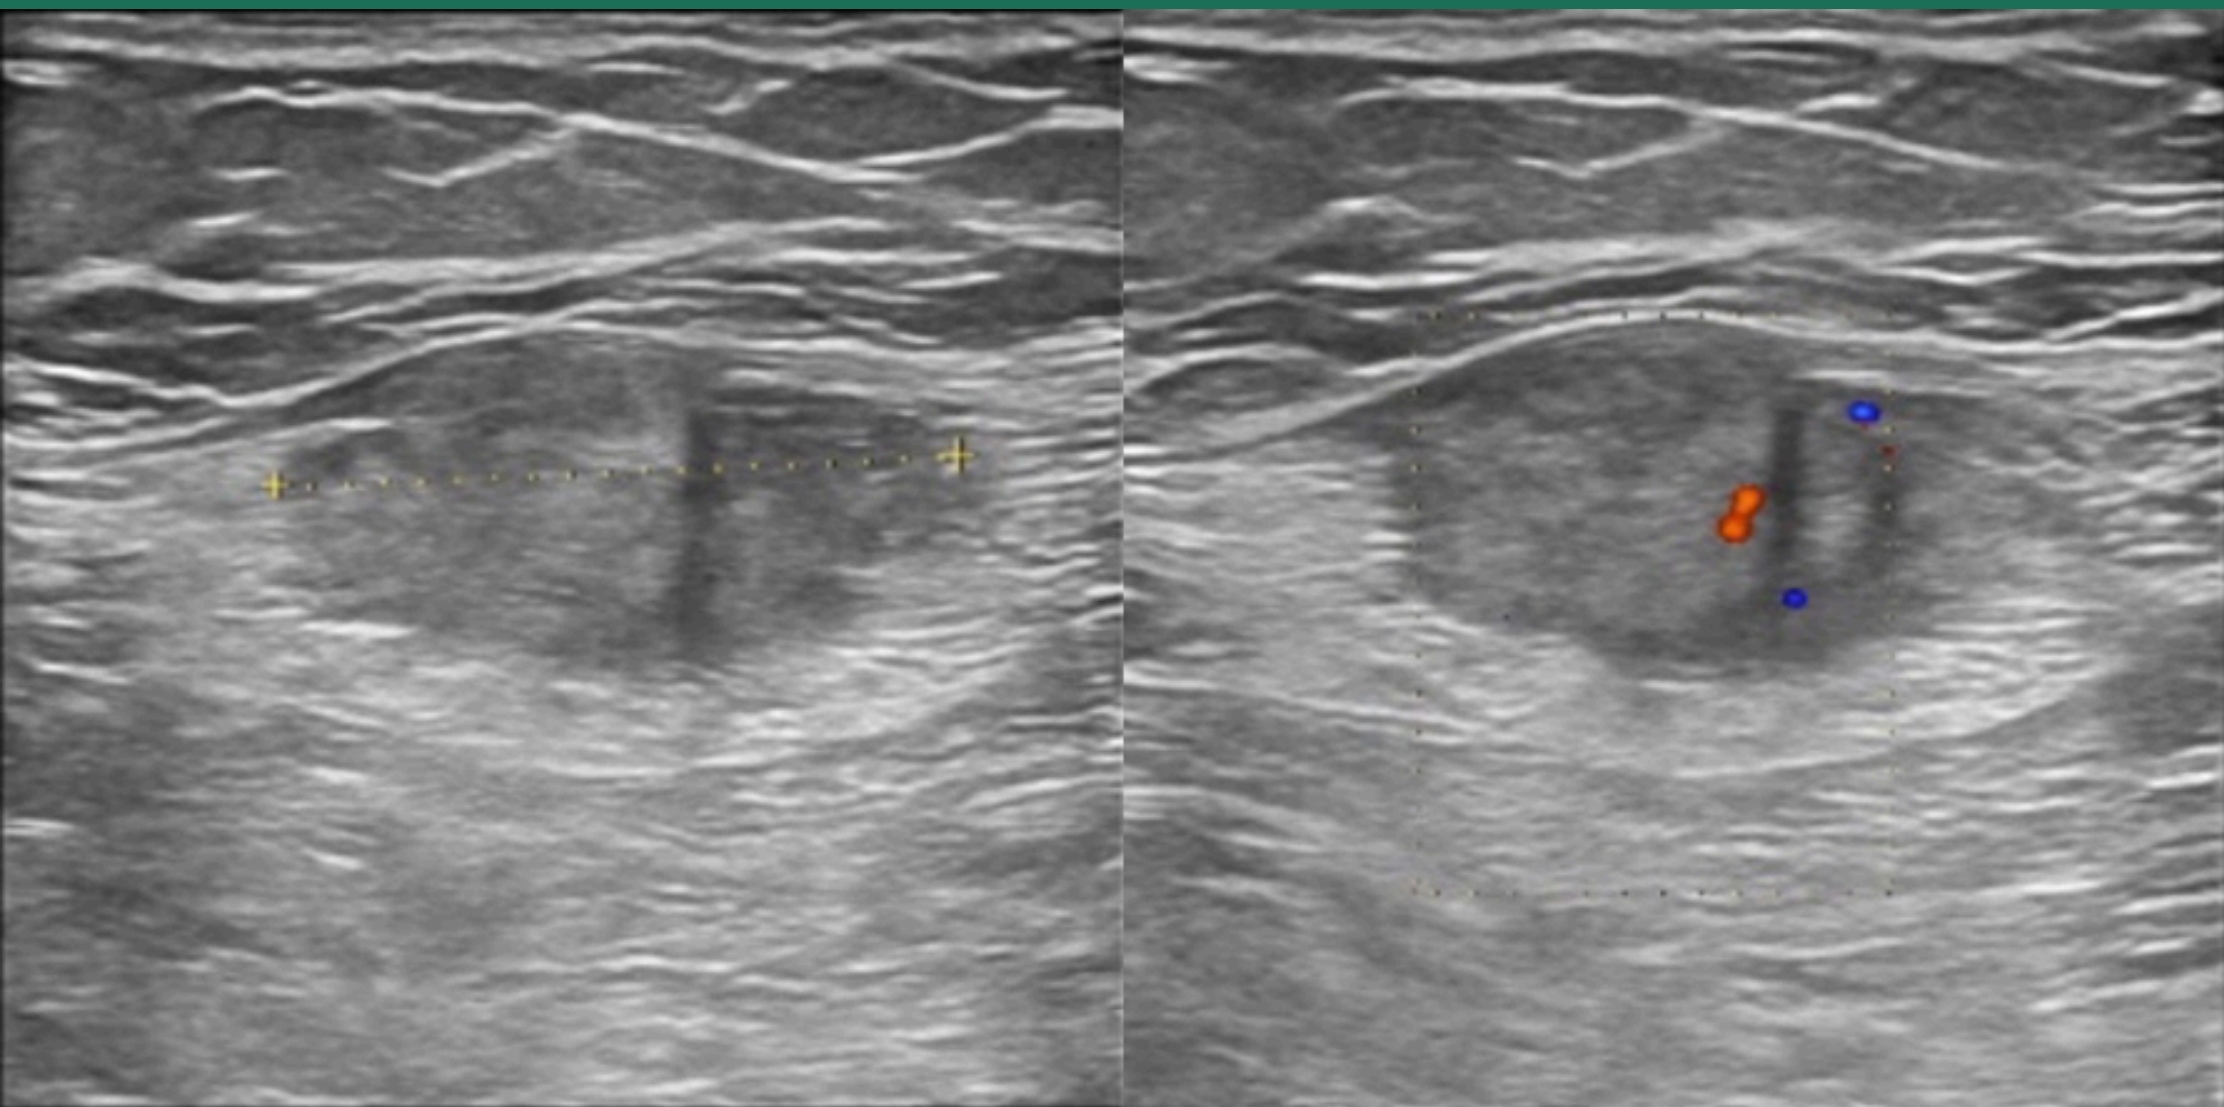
Follow-up ultrasound on the left demonstrates a persistent well-defined oval lesion in the superficial abdominal musculature, while color Doppler on the right shows internal vascularity, indicating a solid lesion rather than a resolving hematoma.
